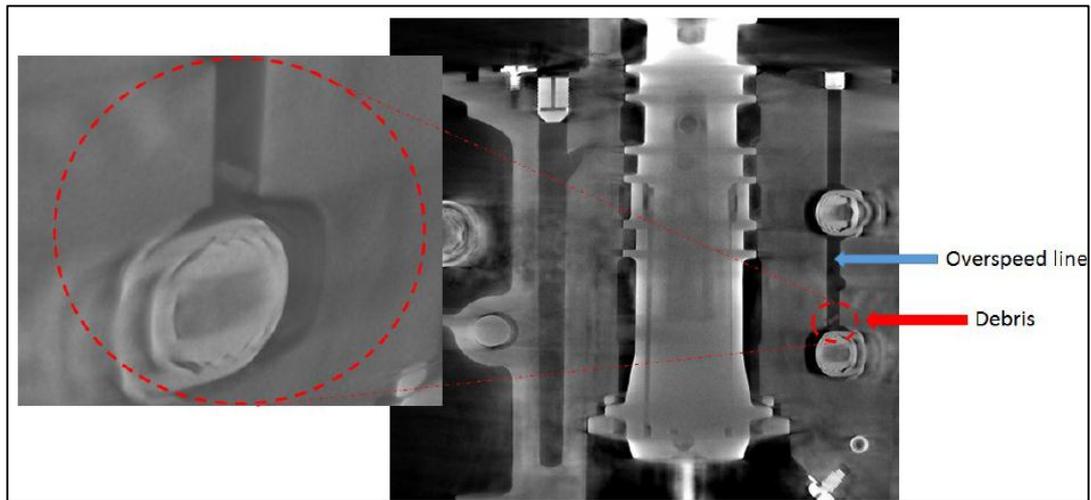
CT Scan Indicating Contamination in Overspeed Line of PVM
